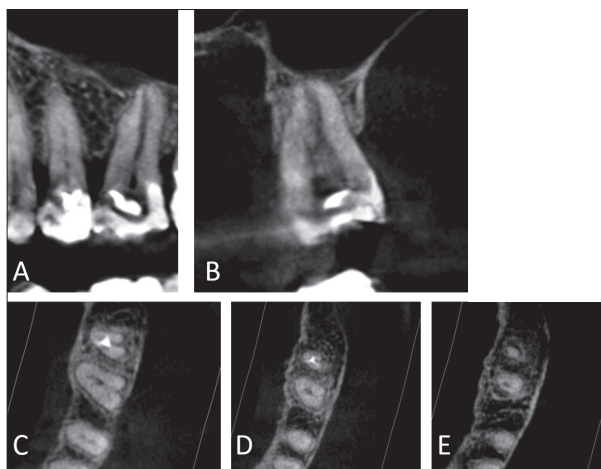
Cone-beam computed tomography images of left permanent maxillary first molar on transversal cross-section (A), sagittal cross-section (B), and axial cross-sections on the coronal (C), medial (D), and apical level (E)
